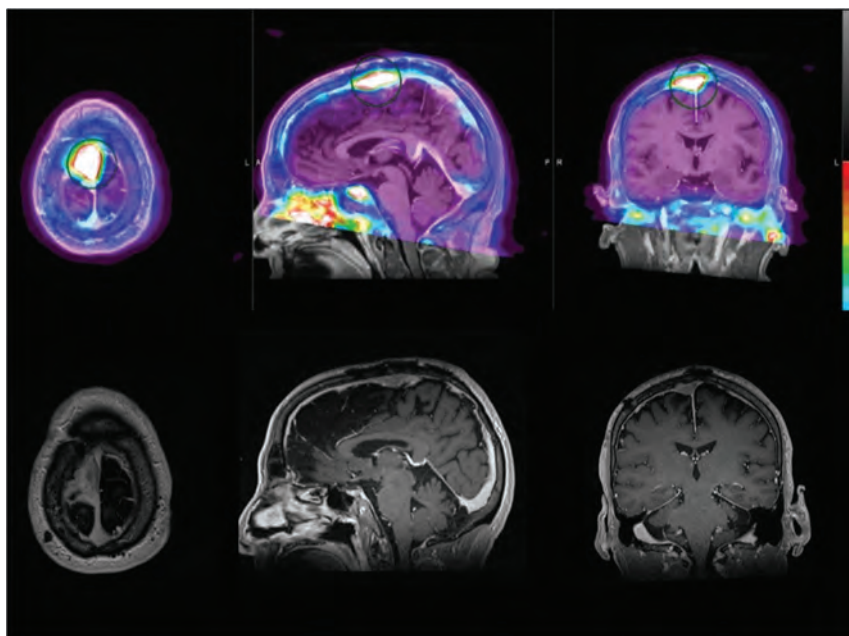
A 69-year-old woman with a SSTR-avid recurrent meningioma in the right frontal parasagittal region and associated invasion of the calvaria and superior sagittal sinus. Incidentally noted is SSTR-positivity in the left temporomandibular joint with prominent articular/periarticular enhancement, suggestive of inflammatory/infectious arthritis. In this example, SSTR-PET/MRI findings are more extensive than on the basis of structural imaging because calvarial invasion was not identified by contrast-enhanced MR imaging of the brain.
